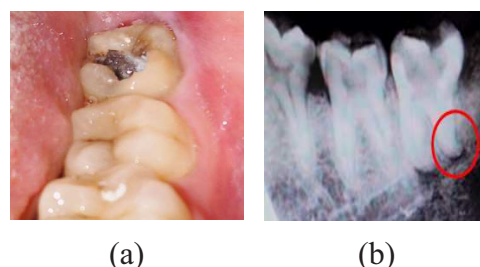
(a) Preoperative clinical picture, (b) Radiographic diagnostic picture.
